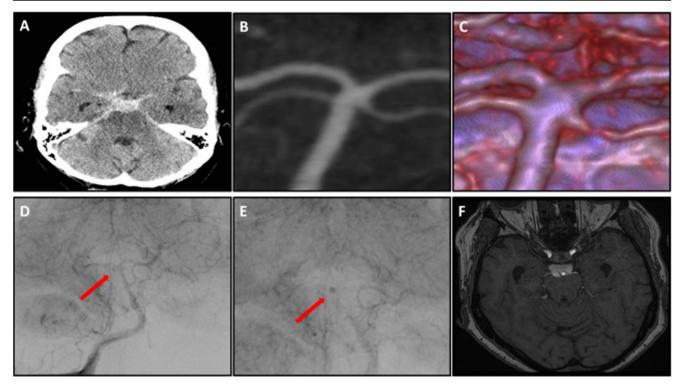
Non-contrast CT at presentation, axial cut (a) shows a subarachnoid hemorrhage limited to the interpeduncular, ambient cisterns, base of Sylvian fissures. b, c CTA shows a normal basilar artery with its branching area viewed anteriorly. DSA, late arterial time (d, f) shows an
